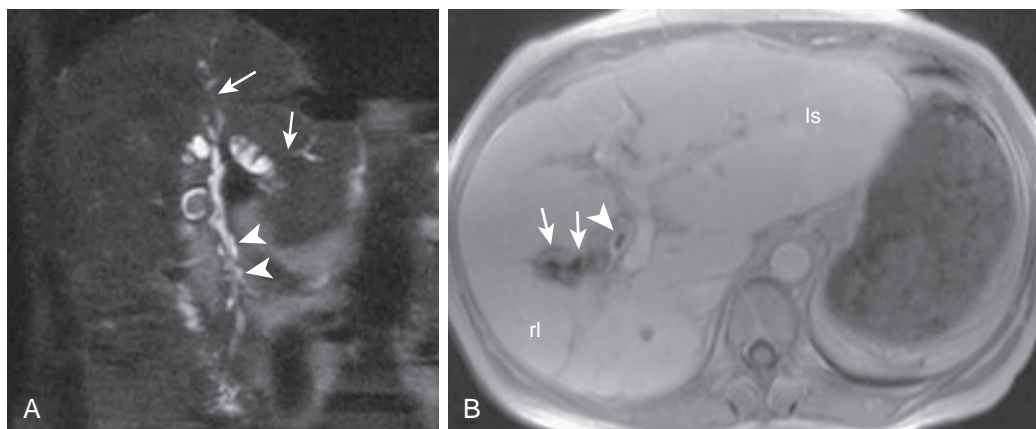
Intrahepatic and extrahepatic primary sclerosing cholangitis. A. Coronal oblique thin-slab MRCP depicts strictures (arrows) and dilation of the intrahepatic bile ducts and marked mural irregularity and diverticulum-like outpouchings of the extrahepatic bile duct (arrowheads). B. Axial, T1-weighted, fat-suppressed, enhanced image of the abdomen reveals cirrhosis complicating PSC as evidenced by lateral segment (ls) hypertrophy and right lobe (rl) atrophy. Thickening and enhancement of the wall of the proximal extrahepatic bile duct (arrowhead) is noted as well as intrahepatic ductal dilation (arrows).
